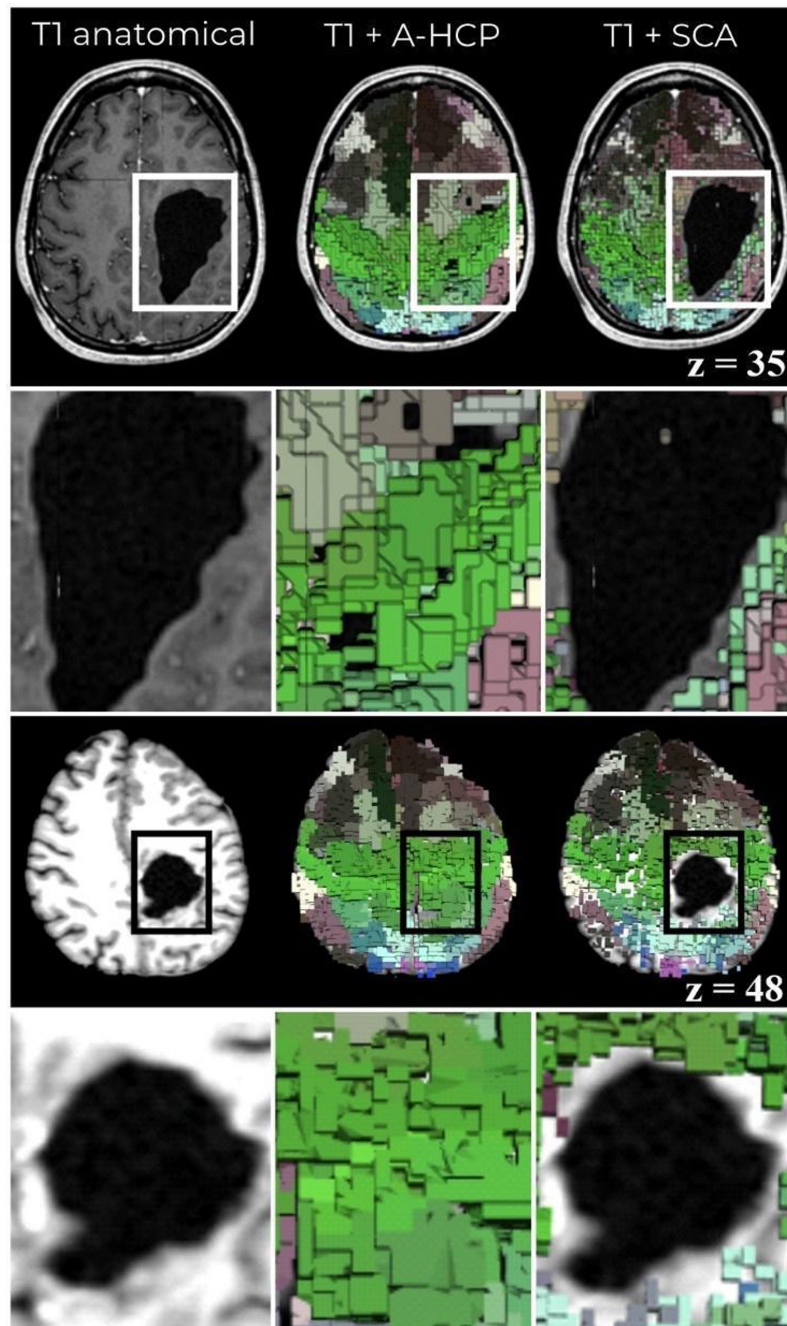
Personalized brain mapping resolving functional areas around structural pathology. Left column: a T1-weighted image showing the location and extent of structural damage. Middle column: a typical brain atlas overlaid on the T1 image, demonstrating an inability to account for structural damage. Right column: The Structural Connectivity Atlas (SCA) personalized brain mapping technique, showing that brain regions are mapped in accordance and surrounding structural damage.
